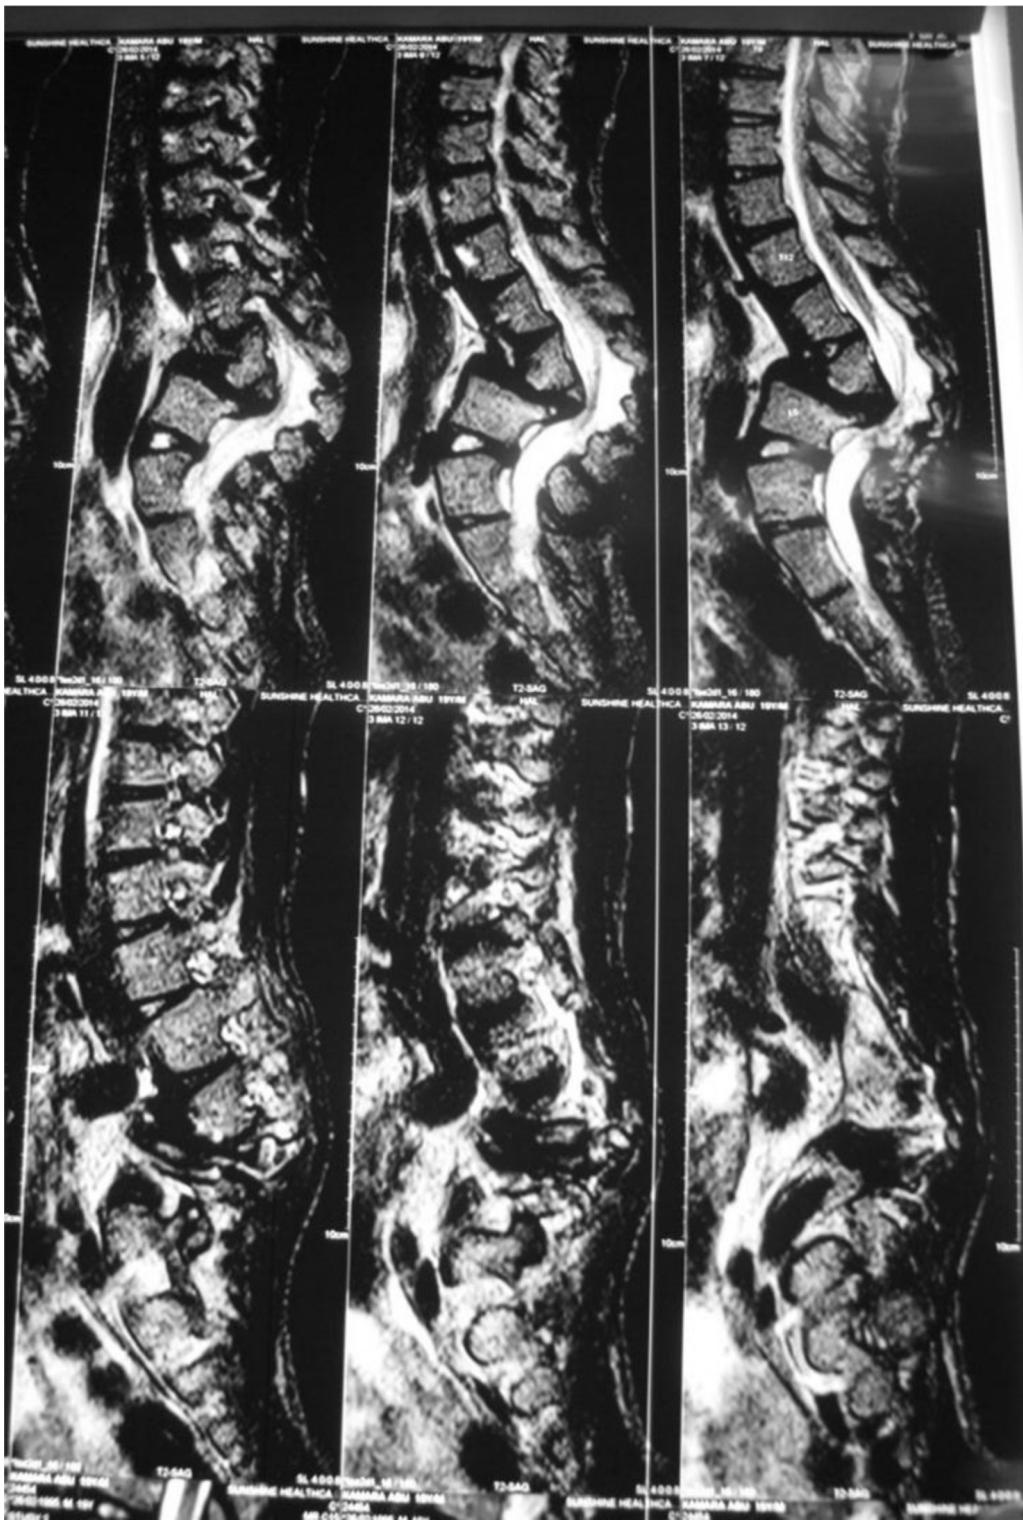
Preoperative sagittal T2-weighted image of lumbar spine.
